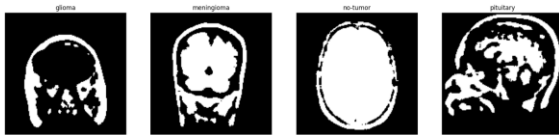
Sample of brain MRI images after preprocessing and segmentation.
